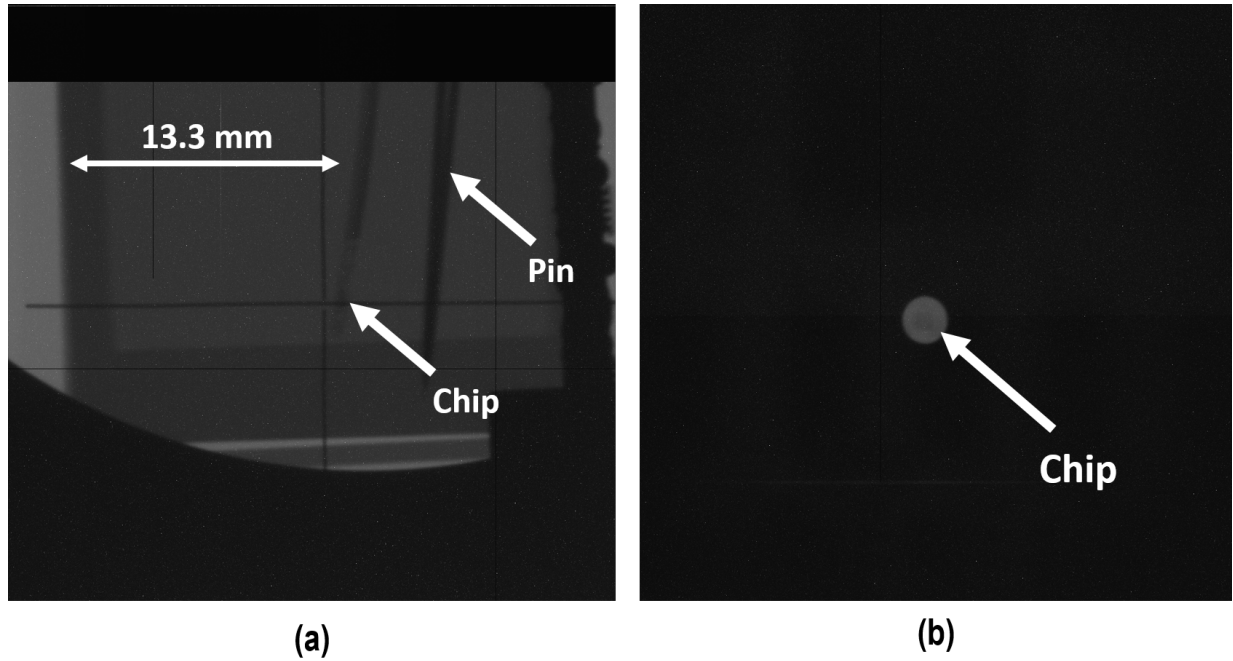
X-ray photo of the setup of (a) lateral and (b) AP view.
